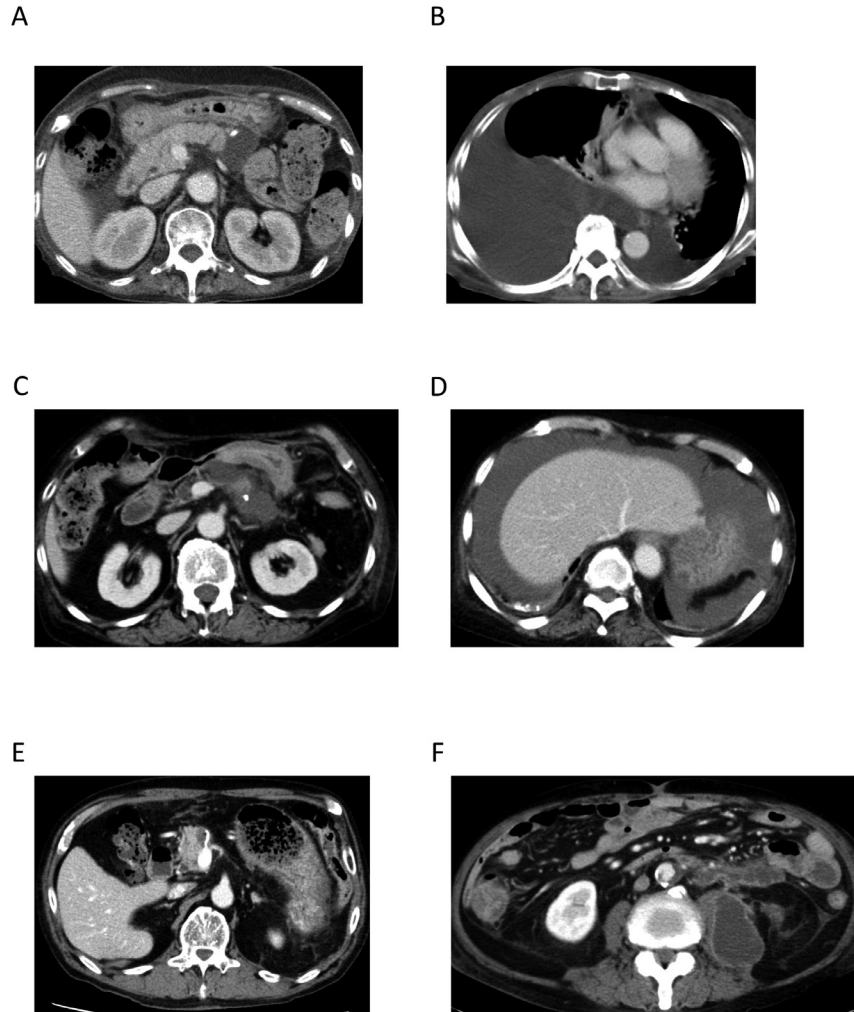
CT scan before discharge hospital and at the onset of delayed pancreatic fistula.
